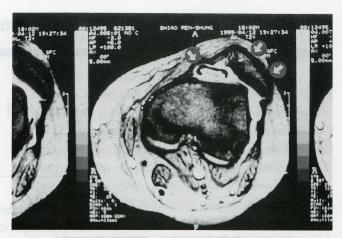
T1-weighted MR image showing a hypointensesignal tumor in the patellofemoral joint. The signal intensity of the tumor surface and joint cartilage are similar. Note that the patella is located in a lateral position. Fig. 2a. Axial view. Fig. 2b. Sagittal view.
